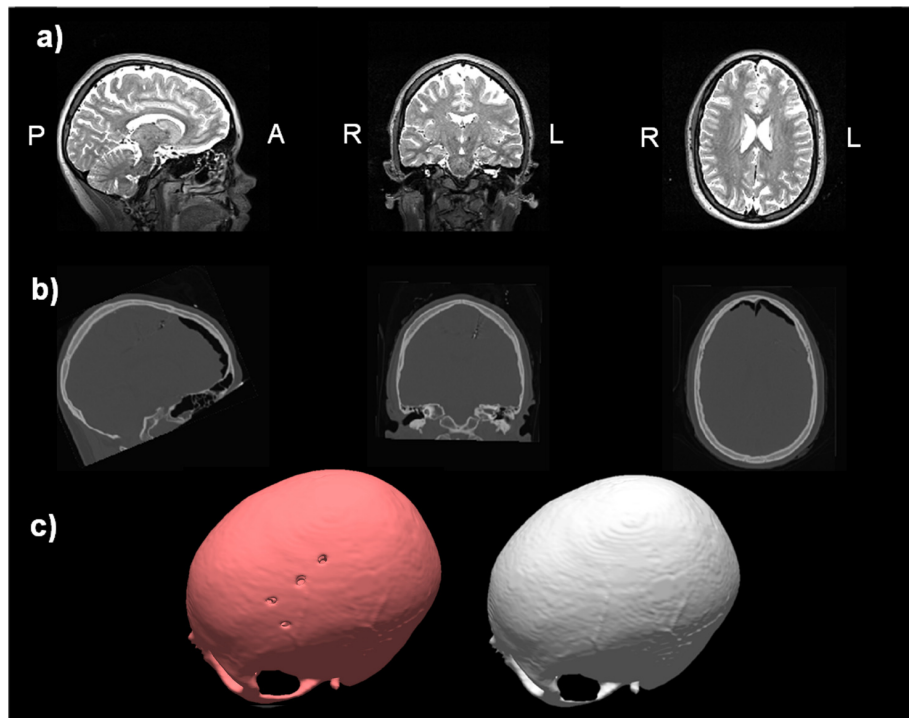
Patient's image data: Sagittal (left column), coronal (middle column) and axial (right column) slices of a) FLAIR MRI (upper row), b) CT (middle row) and c) the reconstructed surfaces of the skull with and without the burr holes (left and right column and light red and gray, respectively). Anterior (A), Posterior (P), Left (L) and Right (R) indicate MRI/CT orientation.
